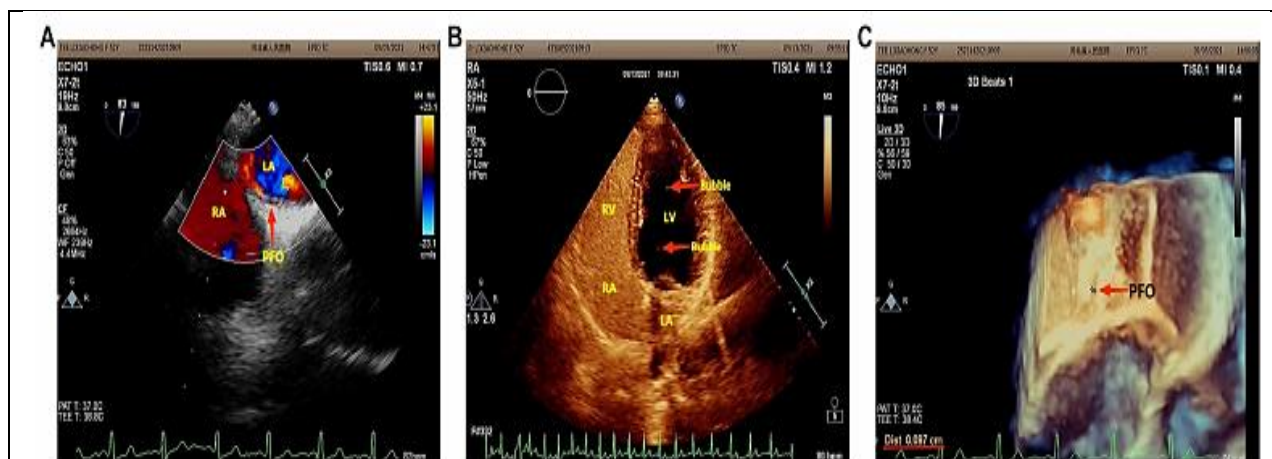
(A) Agitated saline contrast echocardiography revealed that the greatest number of bubbles in a single frame following the Valsalva maneuver was less than 10 bubbles (RLS 1) in three cardiac cycles. (B) A two-dimensional transesophageal heart echocardiogram revealed a 0.9 mm-wide fissure echo in the atrial septum's middle ovoid fossa. (C) Three-dimensional echocardiogram of the transesophageal heart: Following the Valsalva maneuver, the atrial septum's ovoid fossa measured 0.9 mm in width.
